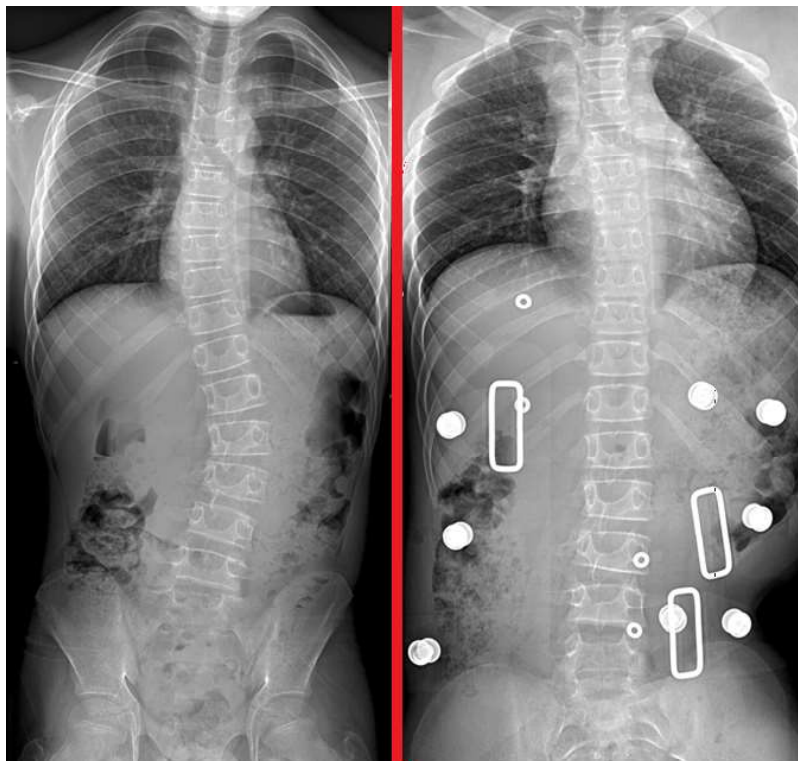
Anteroposterior plain film radiograph of a patient with major lumbar curve of 36 degrees prior to bracing [left] and a radiograph of the same patient in brace demonstrating curve correction while in a brace [right].
